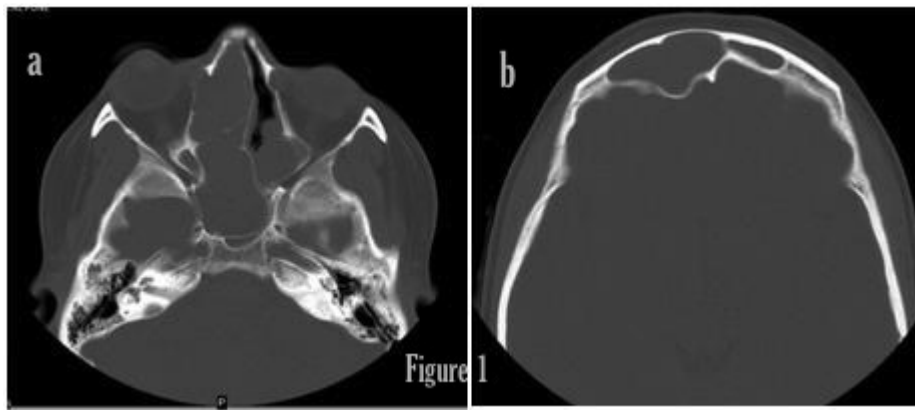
(a) and (b) Axial Noncontrast CT Image in bone window shows expansion of sphenoid, ethmoid and right frontal sinus. Intraorbital extension and intracranial extension seen
